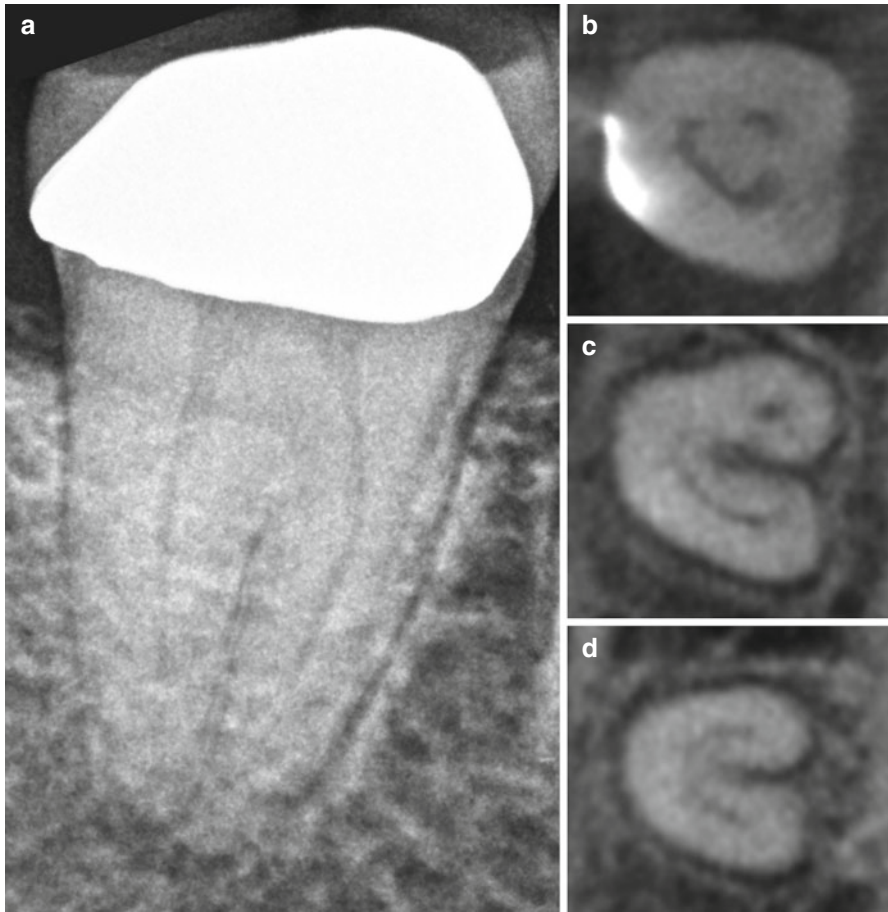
Preoperative periapical radiograph of a mandibular right second molar (a) with corresponding axial CBCT slices captured from the coronal third (b), mid-root (c), and apical third (d) demonstrating a C-shaped external root form and C-shaped internal root canal configuration
